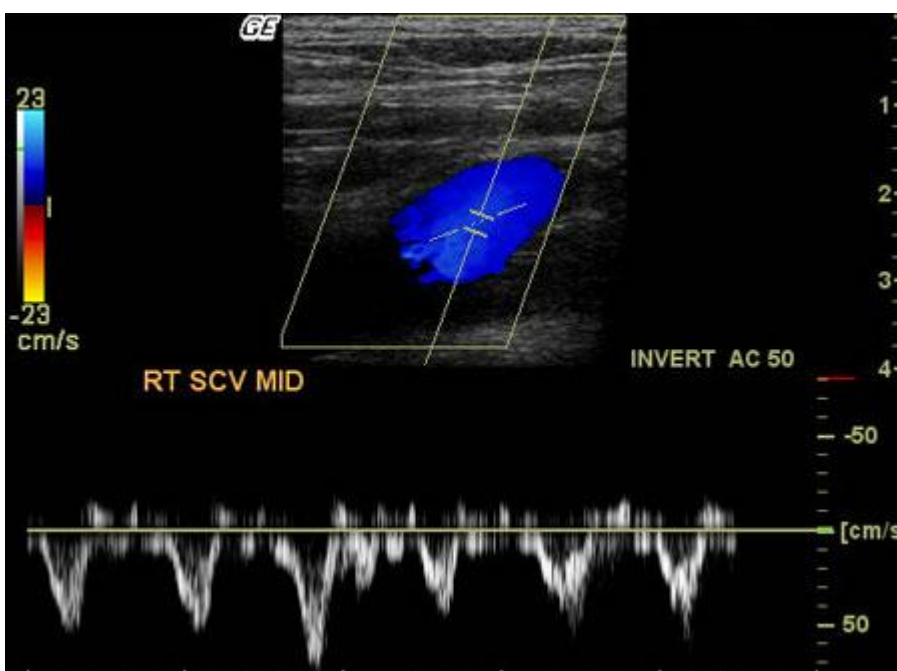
The Doppler velocity tracings from the central veins (subclavian, internal jugular and subclavian) will typically have a pulsatile appearance. Forward flow into the atrium causes a sharp increase in blood flow velocity that decreases as the atrium fills. Blood flow will then reverse as the ventricle contracts and some of the blood in the atrium can flow retrograde.
